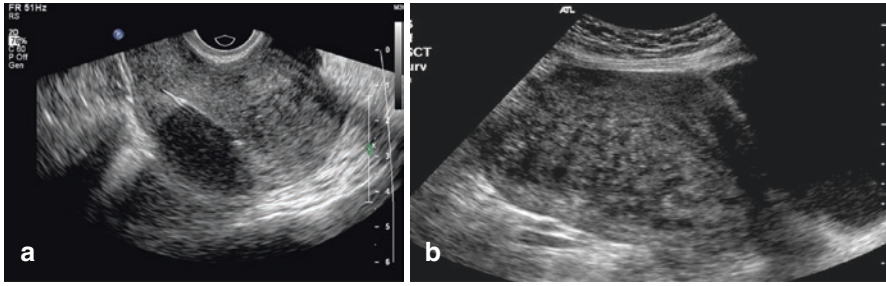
(a) TVUS image of adenomyosis. The uterus is retroverted. The picture shows the echotexture of the posterior uterine muscle layer changes, with uneven echo and thickened wall; meanwhile, the intrauterine cavity shows the high echoes of the Mirena IUCD, and the sound shadow behind it. The echoes of the myometrium of the anterior wall of the uterus are not seen clearly (b) Transabdominal ultrasound image of adenomyosis. The uterus is anteverted; the picture shows that the echo of the posterior wall of the uterus is obviously uneven and rough, and the hypoechoic stripes and hyperechoic stripes or nodules alternately exist. The arrangement is disordered, and the posterior wall is significantly thicker than the anterior wall
